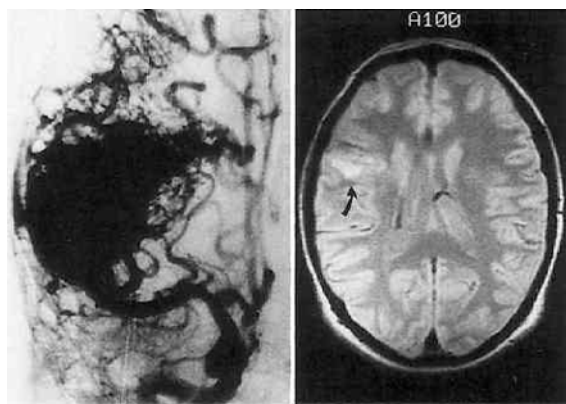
Case 11. *Left:* Cerebral angiogram demonstrating a large arteriovenous malformation (AVM) supplied by the right middle cerebral and anterior cerebral arteries. *Right:* Axial T<sub>2</sub>-weighted magnetic resonance image obtained 5 years after treatment with 4500 cGy of irradiation showing increased signal (*arrow*) at the site of the previously identified AVM.
